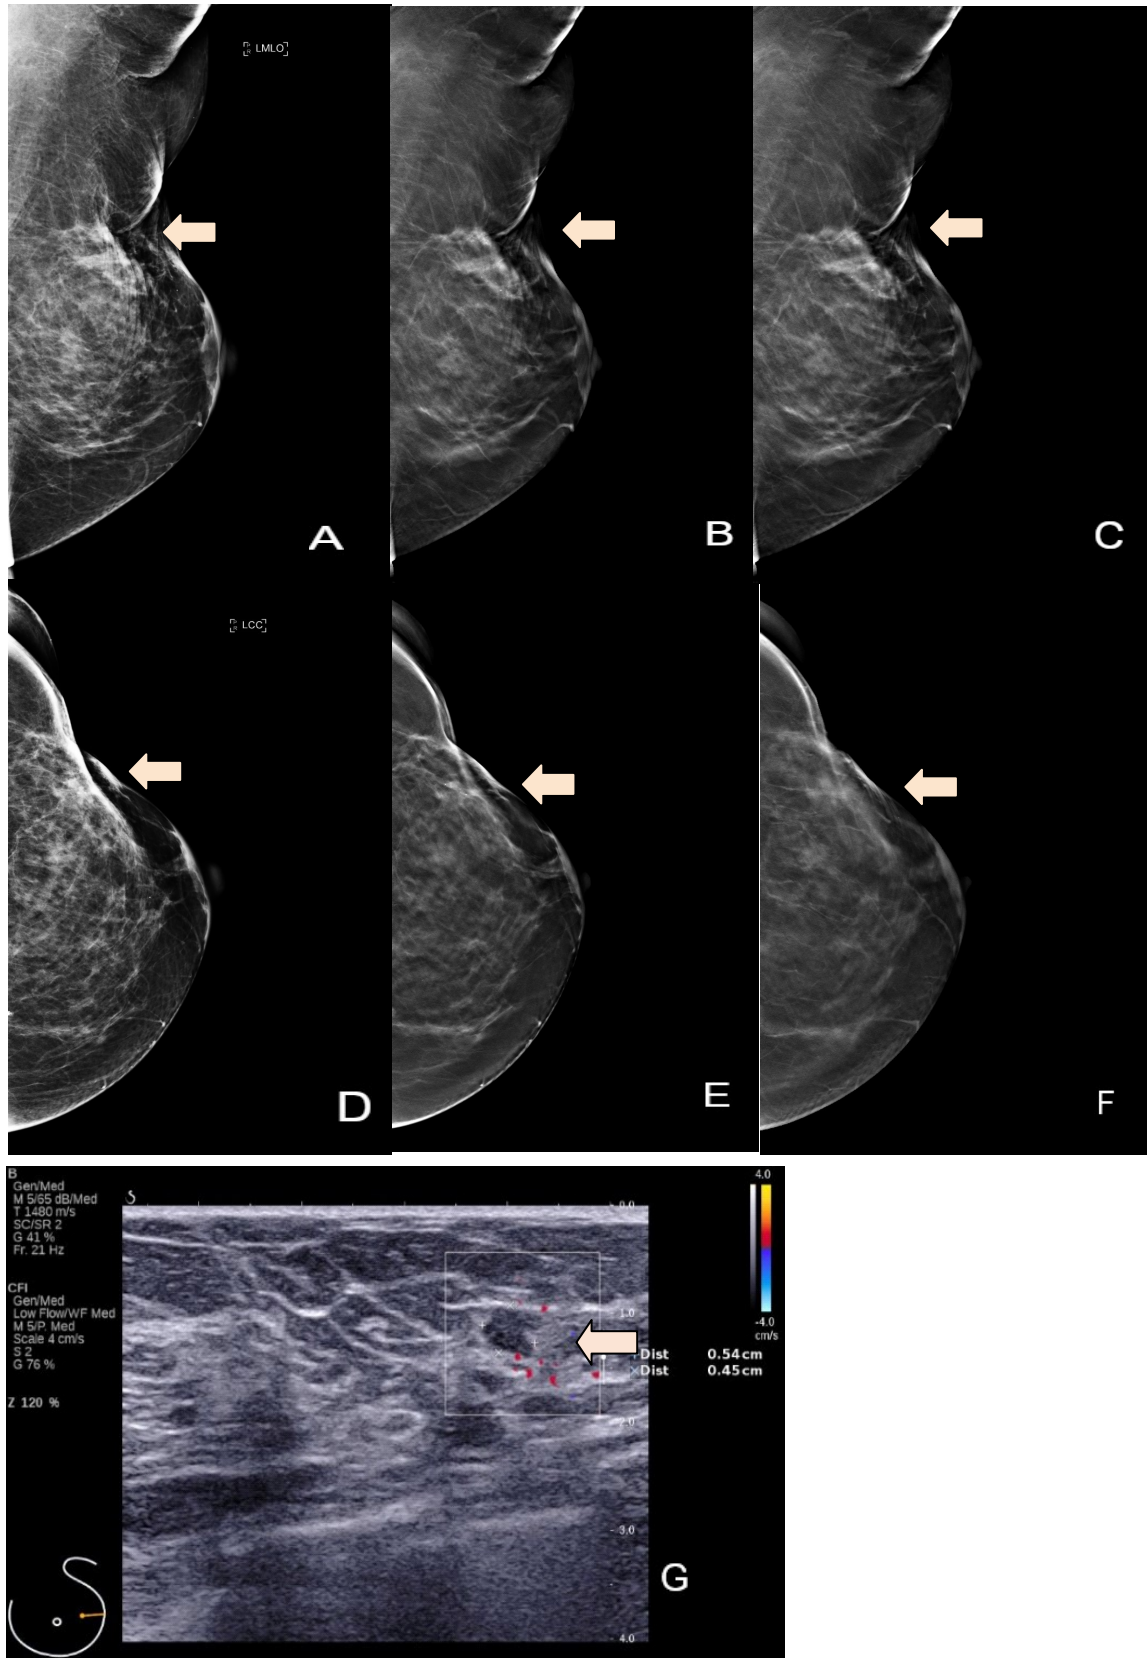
A 67-year-old female patient who had undergone BCT at left upper outer quadrant (pathology = invasive ductal carcinoma grade 2 with extensive ductal carcinoma in situ) for surveillance at 6 months, (A and D) DM left MLO and left CC views show suspicious asymmetrical density and architectural distortion at left outer mid part (arrows). (B, C, E and F) DBT left MLO and left CC views show irregular shape mass with indistinct margin at left outer mid part (arrows). (E) Ultrasonography of left breast shows a 4.5 x 5.4-mm well-defined lobulated hypoechoic nodule without definite internal vascularity at left outer mid part, suspicious lesion for recurrence. Then she went to re-excision (pathology = invasive ductal carcinoma grade 3 with 10.0% ductal carcinoma in situ).
